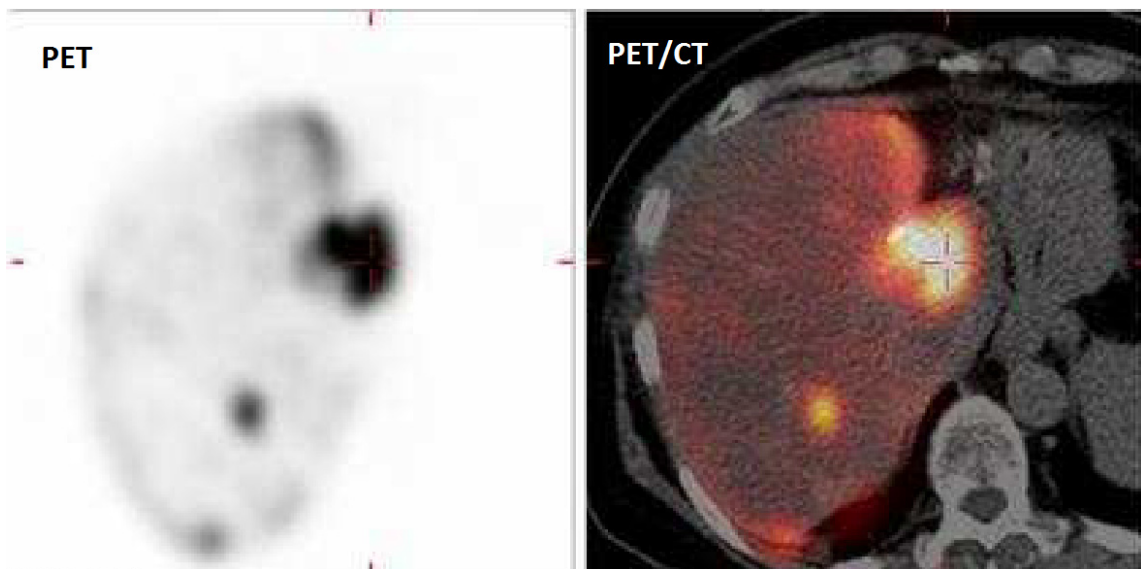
PET/CT image of ^{68}Ga -MAA used for RMT planning (63)
